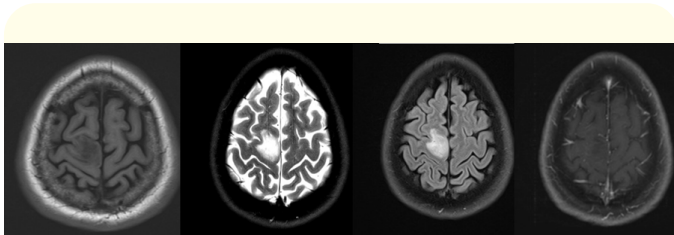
Intraaxial lesion hypointense on T1 (A), Hyperintense on T2(B), no inversion on FLAIR (C), no enhancement on contrast scan (D) suggestive of low grade glial lesion.
